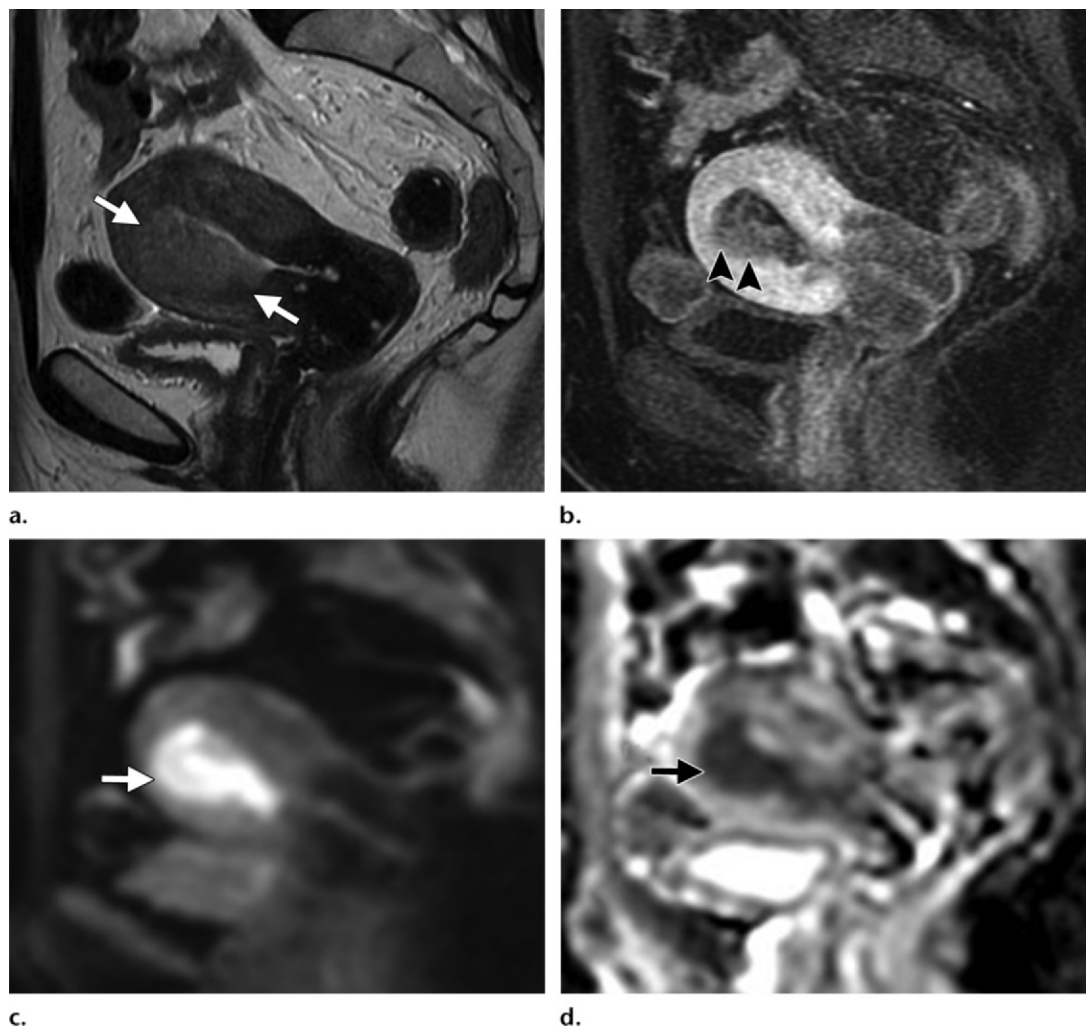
Stage IB endometrial carcinoma (grade 3 endometrioid adenocarcinoma) in a 67-year-old woman. (a) Sagittal T2-weighted MR image shows an intermediate- to high-signal-intensity endometrial tumor (arrows). (b) Dynamic contrast-enhanced MR image shows the endometrial tumor (arrowheads), which demonstrates poor enhancement compared with that of the myometrium. (c, d) Corresponding diffusion-weighted image (c) and ADC map (d) show restricted diffusion within the endometrial tumor (arrow), which extends into the outer one-half of the myometrium. The extent of myometrial invasion is clearly delineated on the dynamic contrast-enhanced image, diffusion-weighted image, and ADC map.
